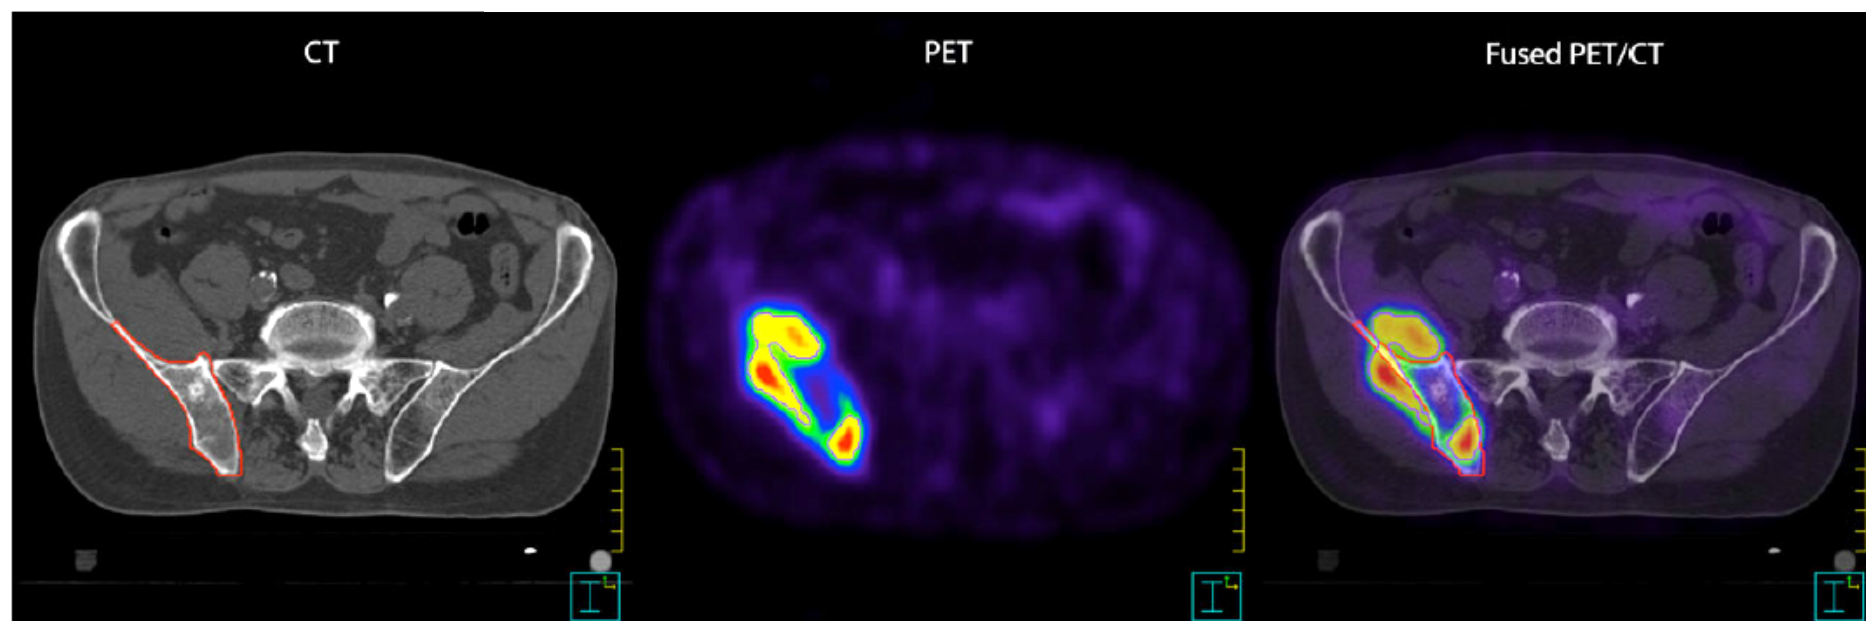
Axial planes of a lung cancer patient who had painful bone metastasis in the right ilium. SUV_{MAX} in the lesion was 13. A relative SUV_{MAX} -window was used. Delineated in red is the GTV_{CT} (243 cc); in purple is the GTV_{PET} (43 cc). The right panel shows the CT, the middle panel shows the ^{18}F -FDG-PET and the left panel shows the fused ^{18}F -FDG-PET/CT. Jaccard Index and overlap indices for this patient were 0.1 and 0.1, respectively. The ^{18}F -FDG-PET/CT show minor regions of uptake in the CT-defined bone metastasis, but shows an extra-osseous component.
